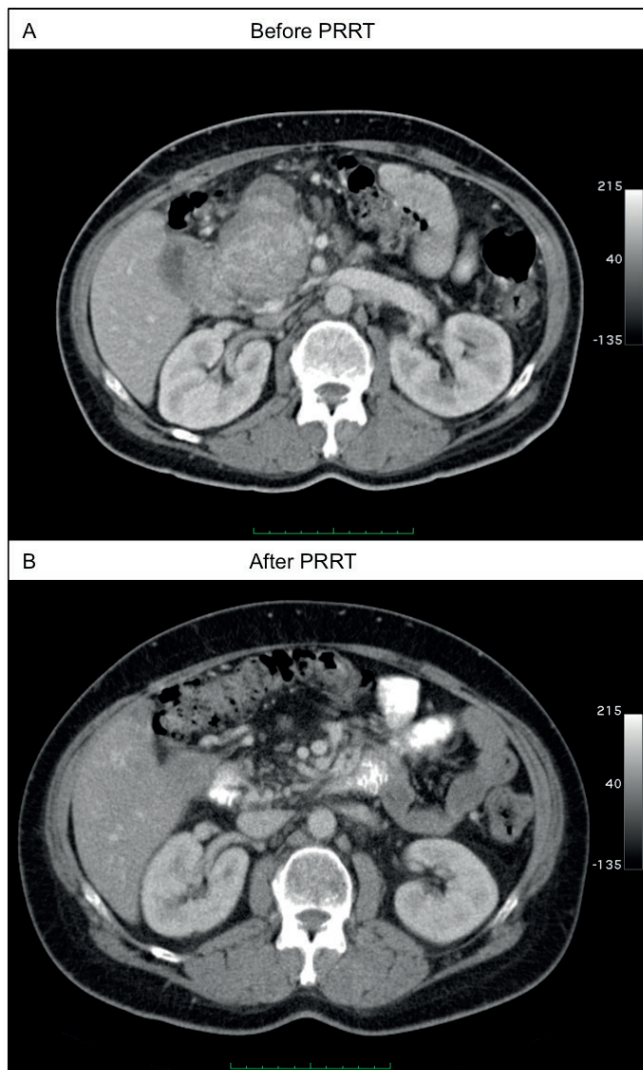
Initially inoperable NET of the pancreas. CT of abdomen before (A) and 3 months after (B) PRRT in 4 cycles with cumulative 29.6 GBq of ^{177}Lu -DOTATATE. This patient had eventually partial remission (PR) as tumor outcome. A successful Whipple procedure plus reconstruction of the portal vein was performed 7 months after the last treatment. Resection edges and lymphnodes were free of tumor.
